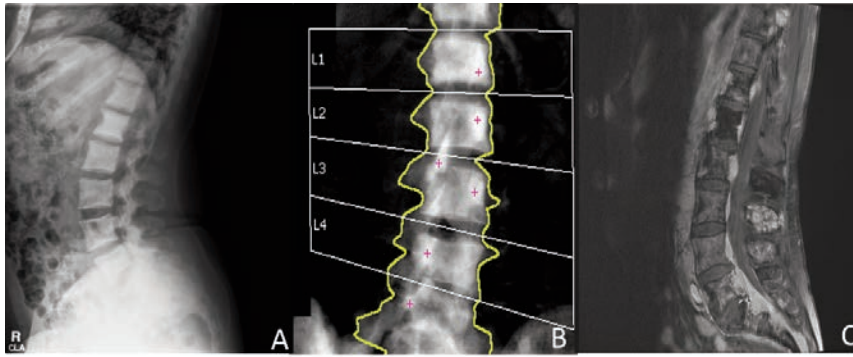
A) Lumbar spine X-ray showing sclerotic lesion in L1 vertebral body. B) Bone densitometry scan showing higher scores in L1 vertebral body (t-score 9.0; z-score 10.2). C) Sagittal lumbar magnetic resonance imaging showing decreased T1 signal at L1 vertebral body corresponding to the area of sclerosis seen on radiographs.
